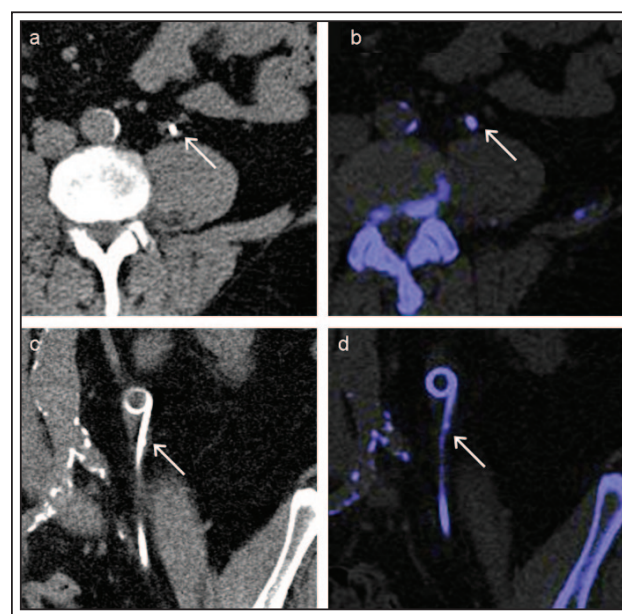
A 64-year-old male with non-uric acid urolithiasis and Bard ureteral stent in the left ureter. The retained stone fragment (arrow) is almost imperceptible on conventional CT (a) axial and (b) coronal images. Both the Bard ureteral stent and the non-UA stone are characterized as blue on DECT (c) axial and (d) coronal images; also causing nearly complete camouflage of the stone fragment. Identification and quantification of stone size are difficult on conventional CT and DECT images without color contrast between the stent and the stone.
